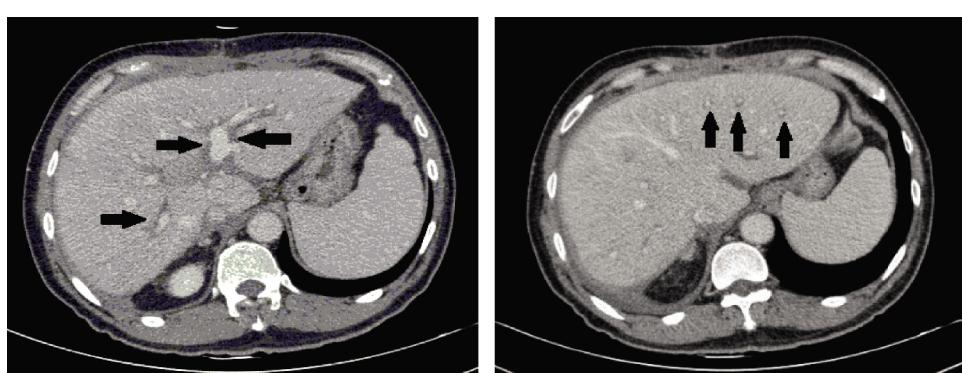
50 岁男性,因乙肝后肝硬化行原位肝移植手术后移植肝正常,术后第 104 天的 CT 示门静脉大分支周围 PVLs(左图黑色箭号)及门静脉周围小分支 PVLs(右图黑色箭号)。
